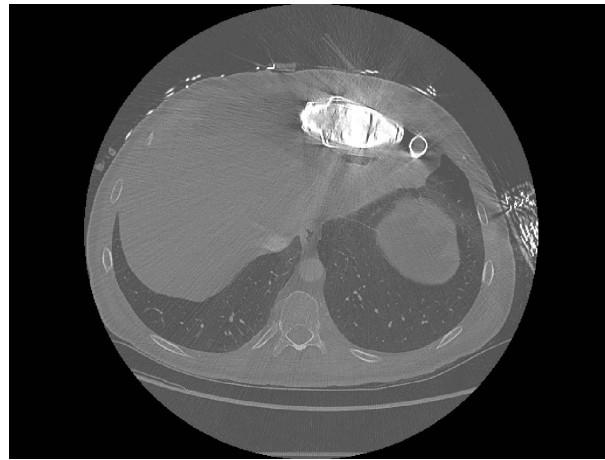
CT-scan slice of a patient with a continuous flow LVAD at the level of the LVAD itself. On the top of the image, the VAD itself and the inflow cannula that connects the left ventricle to the LVAD. Note the noise and artifacts induced by the presence of the device.
